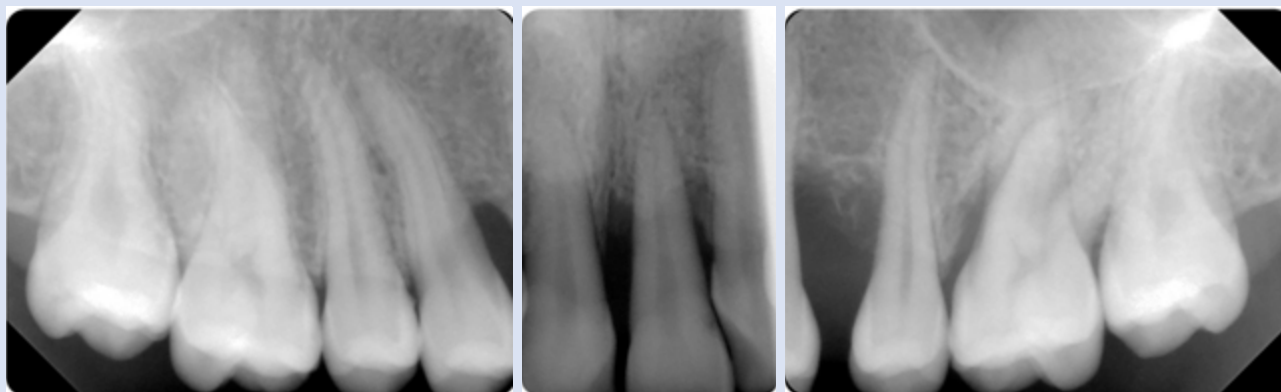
Radiographically, the typical pattern of molar and incisor bone loss is evident at baseline in Case 1.
